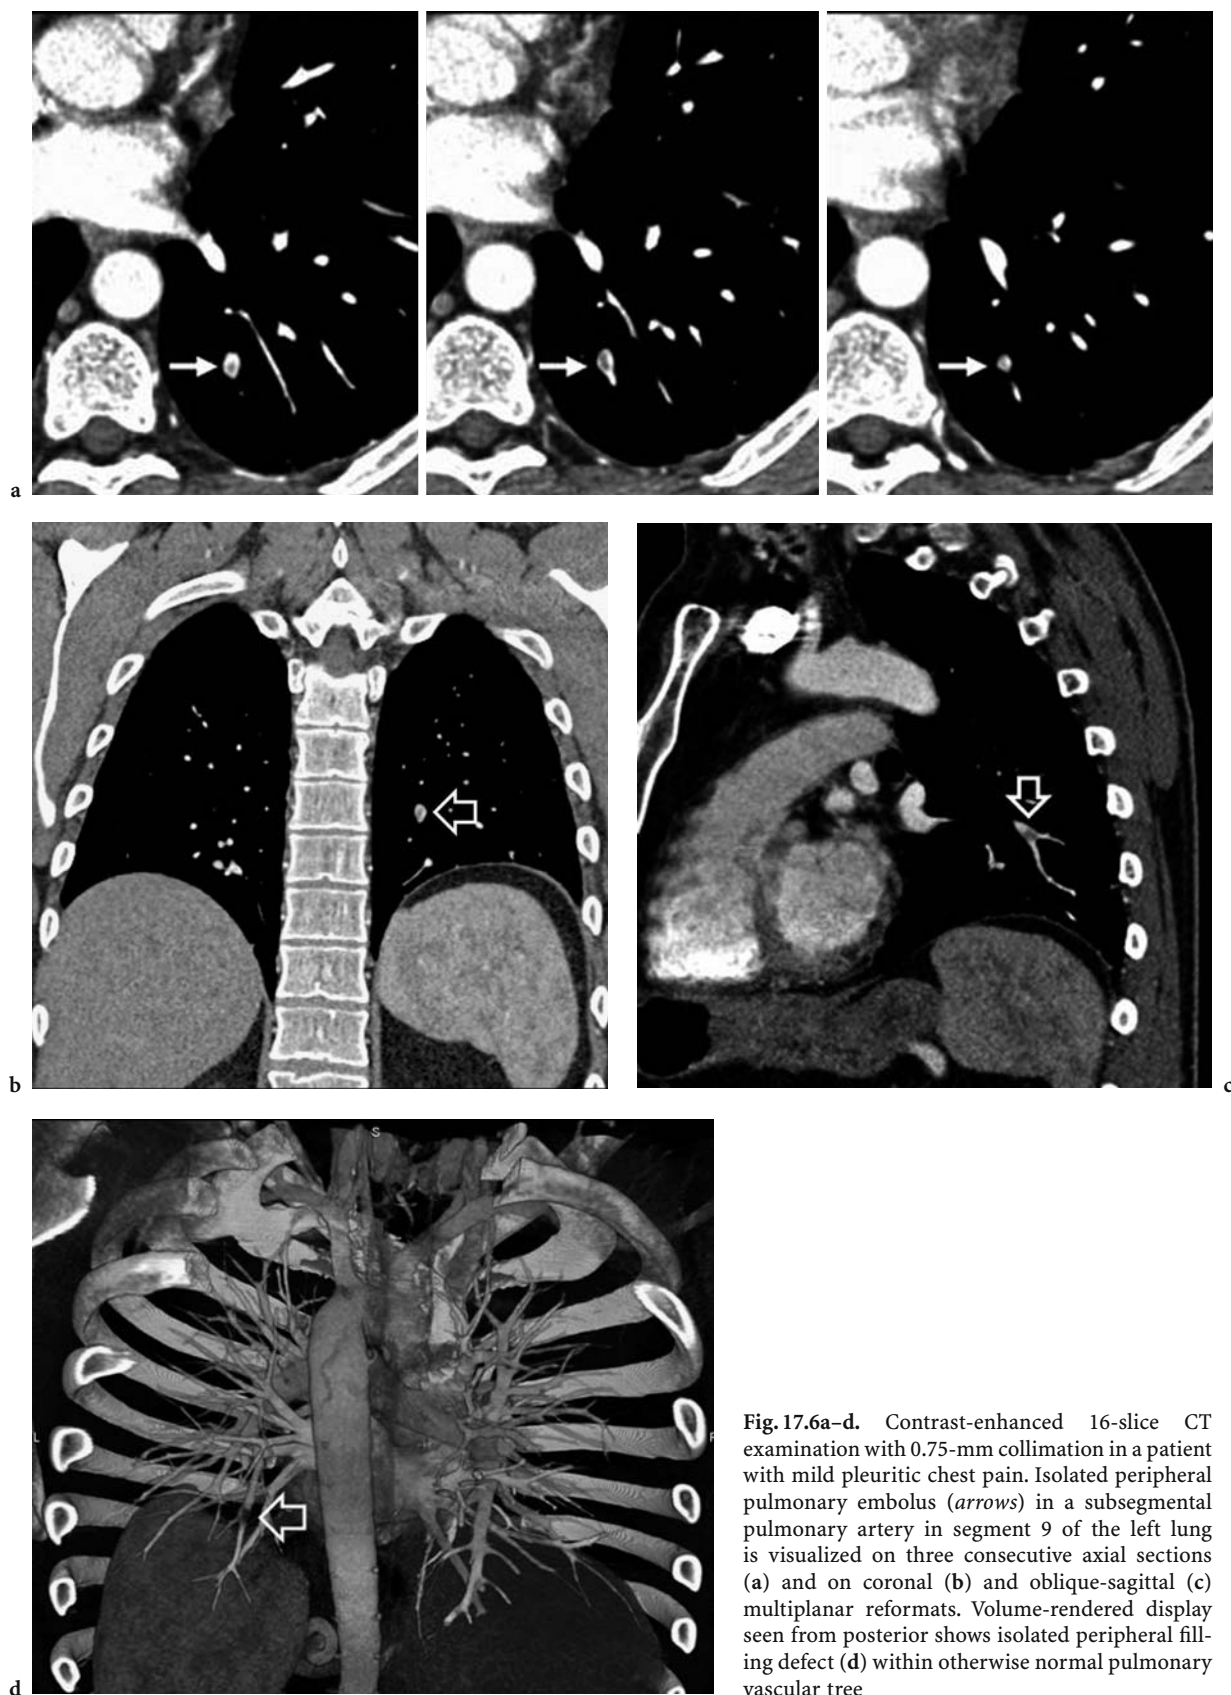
Contrast-enhanced 16-slice CT examination with 0.75-mm collimation in a patient with mild pleuritic chest pain. Isolated peripheral pulmonary embolus (arrows) in a subsegmental pulmonary artery in segment 9 of the left lung is visualized on three consecutive axial sections (a) and on coronal (b) and oblique-sagittal (c) multiplanar reformats. Volume-rendered display seen from posterior shows isolated peripheral filling defect (d) within otherwise normal pulmonary vascular tree
